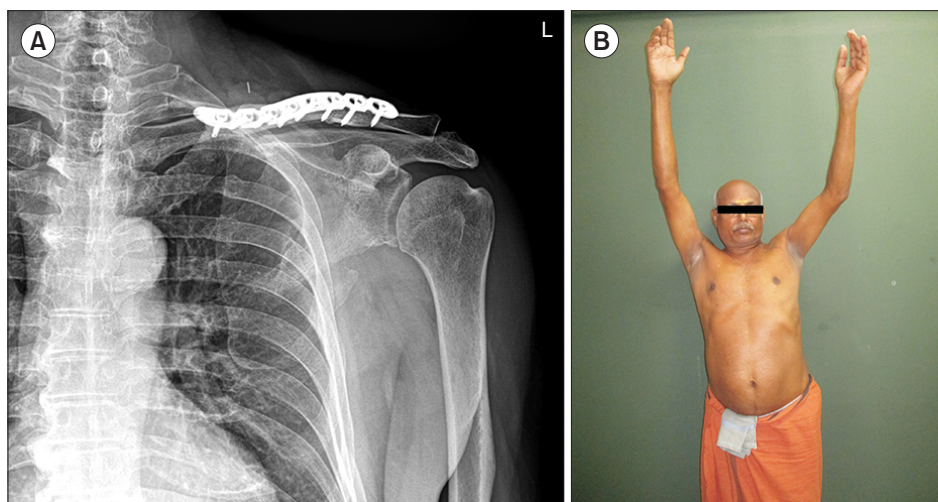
(A) Left shoulder frontal radiograph at three months postoperatively demonstrating healed clavicle and scapula fractures. (B) Clinical photograph of patient at four months postoperatively demonstrating restoration of active left shoulder abduction.
